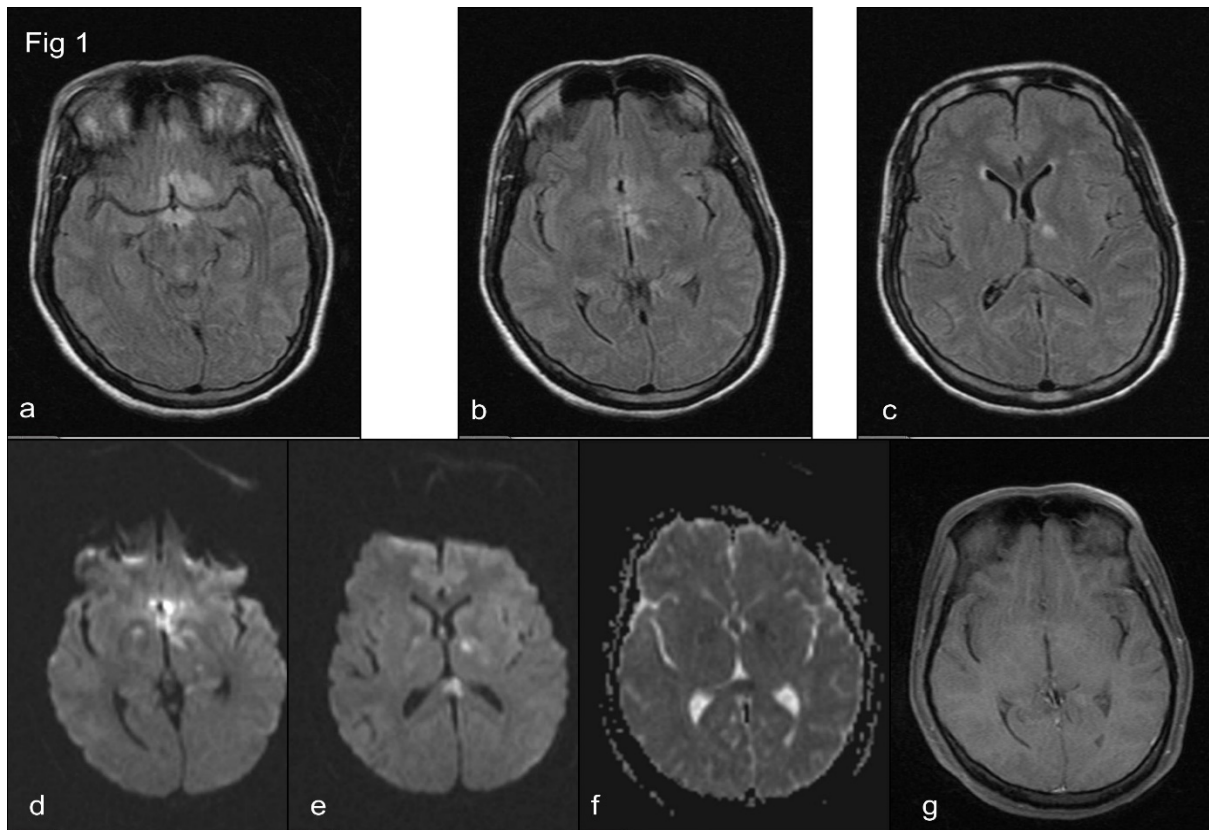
Contrast-enhanced MRI Brain on day 3 of illness showing FLAIR hyperintensities (a to c) involving basifrontal region, mamillary bodies, anteromedial thalamus, and genu of the internal capsule on the left side and splenium of the corpus callosum; with diffusion restriction and ADC mismatch (d to f) and no contrast enhancement (g)
